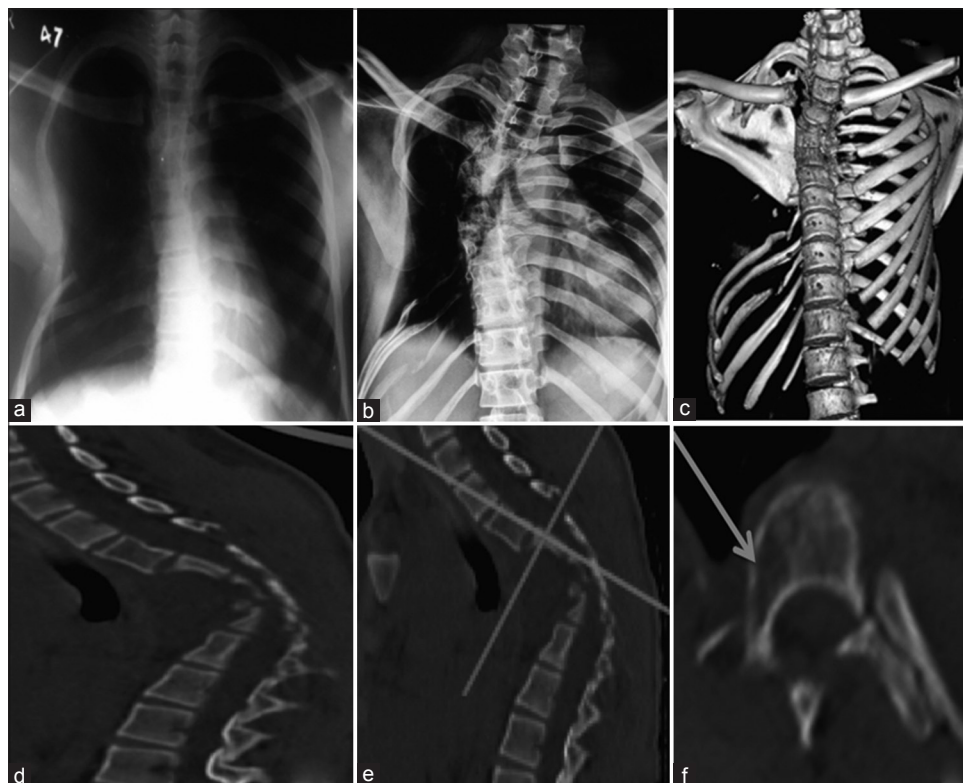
(a) Chest X-ray taken 6 months prior to presentation to us showing mild scoliosis and few absent ribs on the right side (b) X-ray at presentation to us showed right-sided scoliosis with Cobb’s angle 41°. Destruction of ribs has increased as compared to Figure 1a. (c) Three-dimensional reconstruction of the chest (Sternum has been digitally subtracted for better visualization of chest wall,) showing absent ribs on (R) side (4th to 7th rib) (d) Sagittal view showing severe narrowing of the canal at the apex of kyphosis. (e) Dicom image showing the level at which image in Figure 1f has been taken. (f) Axial cut showing osteolysis (arrow) in body and pedicle of vertebrae proximal to the apex
